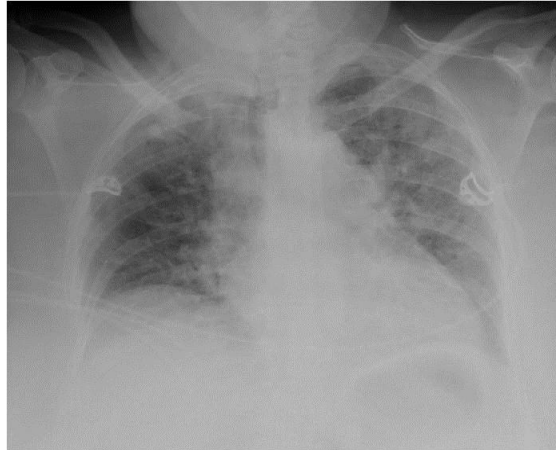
Chest X-ray demonstrating bilateral interstitial infiltrate consistent with pulmonary edema.
